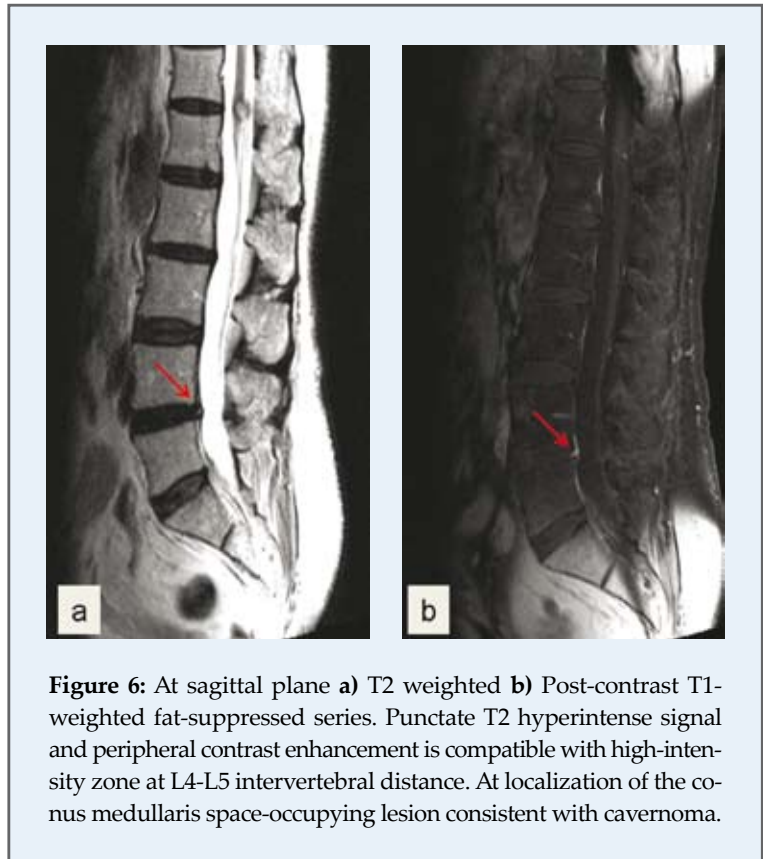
At sagittal plane a) T2 weighted b) Post-contrast T1-weighted fat-suppressed series. Punctate T2 hyperintense signal and peripheral contrast enhancement is compatible with high-intensity zone at L4-L5 intervertebral distance. At localization of the conus medullaris space-occupying lesion consistent with cavernoma.
